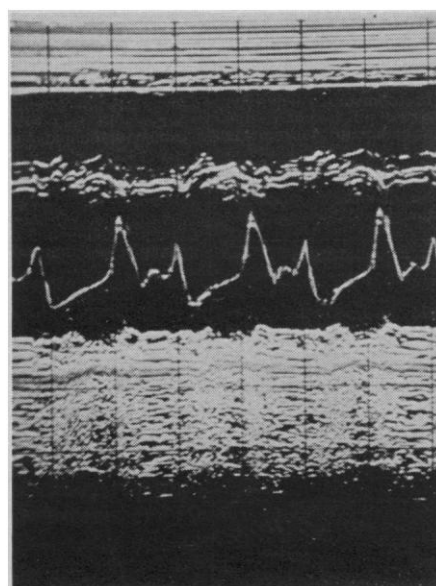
Echocardiogram of a heart with a normal mitral valve (the valve between the left atrium and the left ventricle). In M (motion) mode recordings such as this one, the reflection from a moving structure (here the mitral valve) appears as a line with peaks and valleys. The other reflections are from other heart structures through which the beam has passed, and the intense reflection at the bottom is from the lungs. [Source: Bowman Gray School of Medicine, Winston-Salem, North Carolina]
